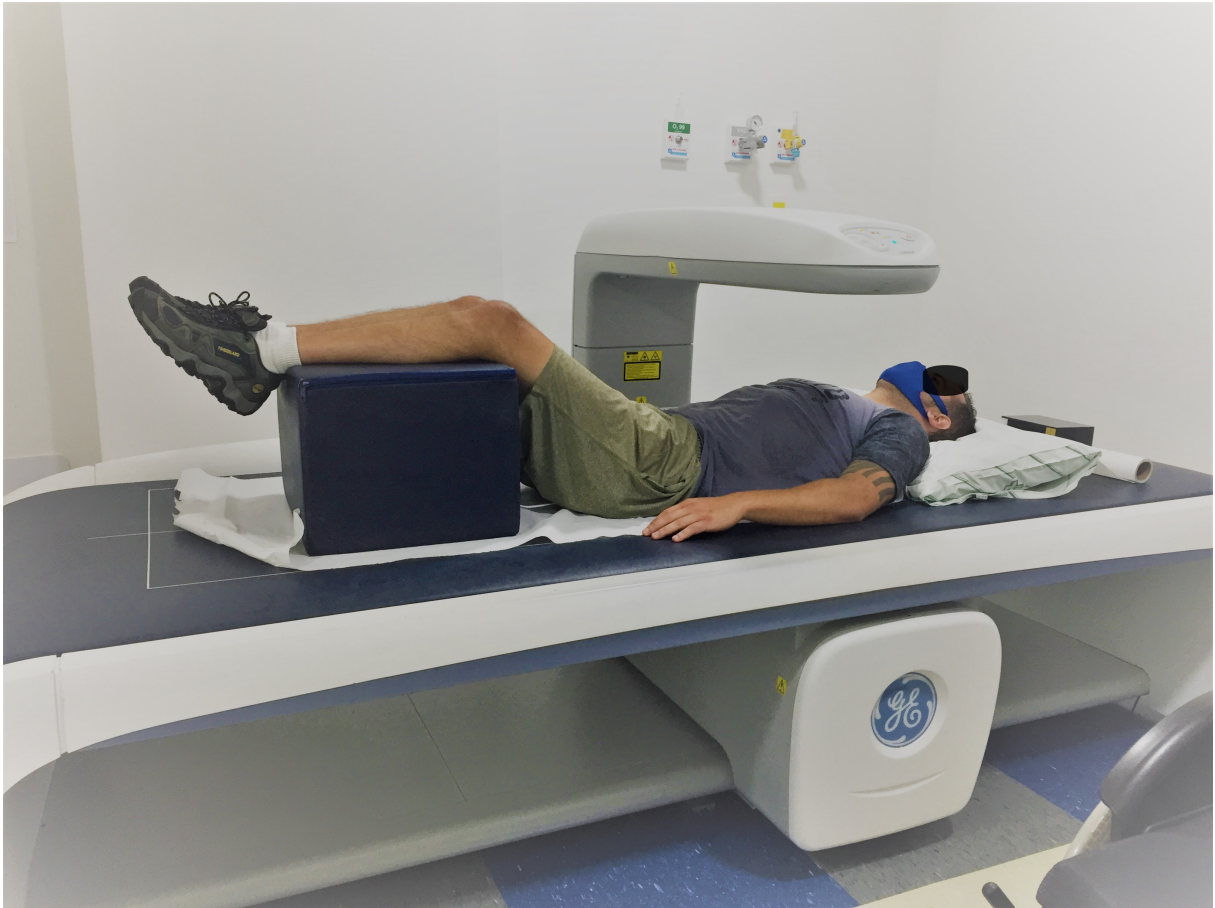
Dual-Energy X-Ray Absorptiometry (DXA) scan test for the Lumbar Spine (LS) BMD assessment.
